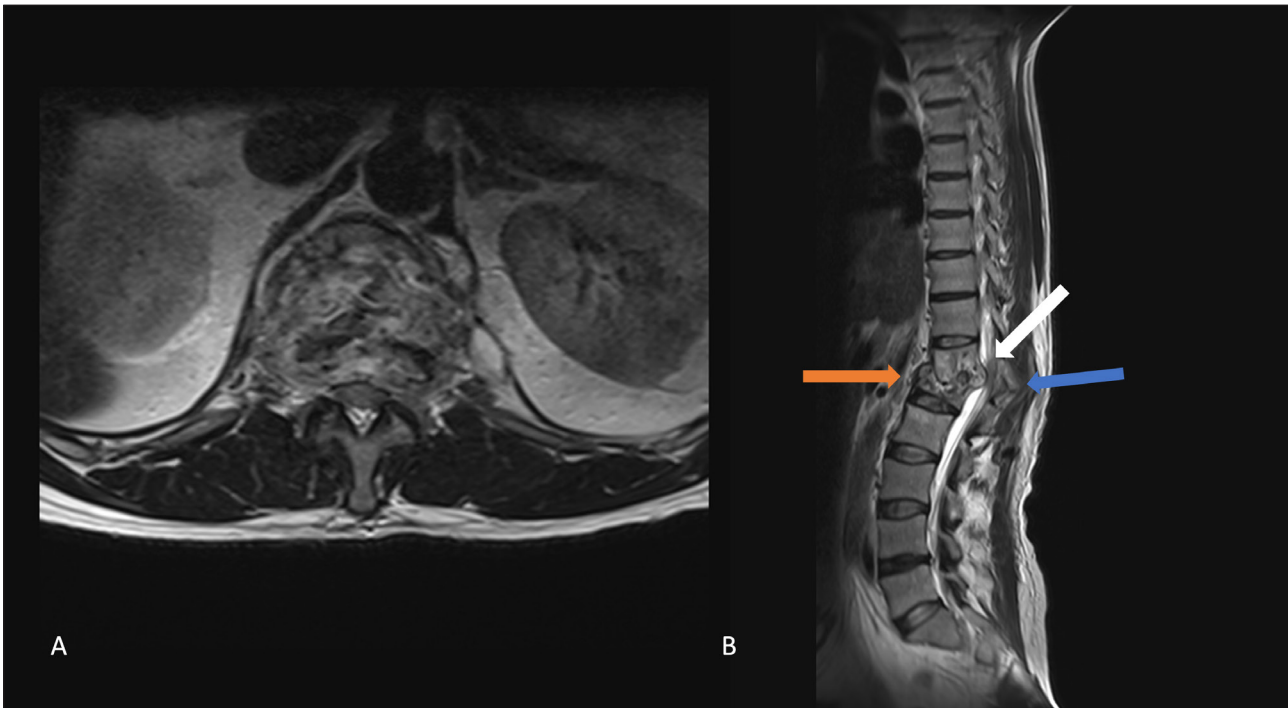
Magnetic resonance imaging findings suggestive of spinal tuberculosis. T2-weighted image showing typical vertebral collapse of Th12/L1 vertebrae with gibbus formation and central canal stenosis. A: transversal view. B: sagittal view; white arrow = central canal stenosis; orange arrow = vertebral collapse of Th12/L1; blue arrow = gibbus formation.
